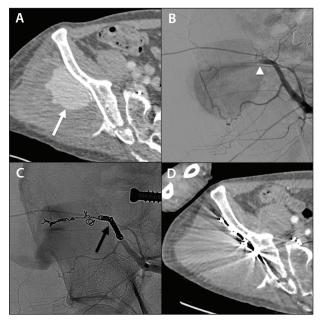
CT showing a 6-cm aneurysm arising from the right posterior gluteal artery (arrow) (A). Angiogram showing a 4-F Cobra C2 angiographic catheter selecting the right superior gluteal artery (arrowhead) (B). Angiogram after embolization showing no contrast flow into the sac (arrow) (C). CT at 3-month follow-up showing that the false aneurysm remained completely occluded (D).
